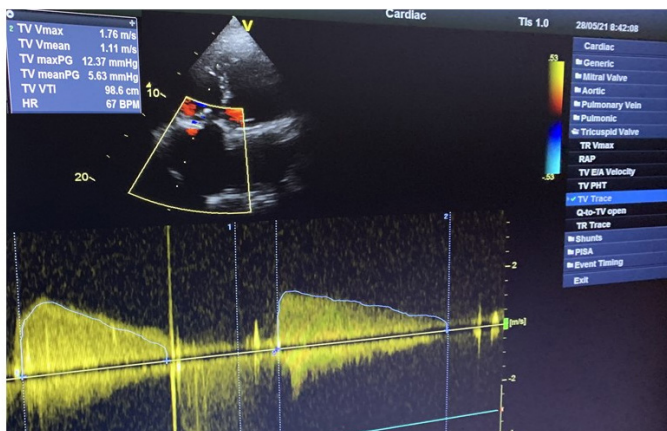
Post-procedure Doppler echocardiographic image
